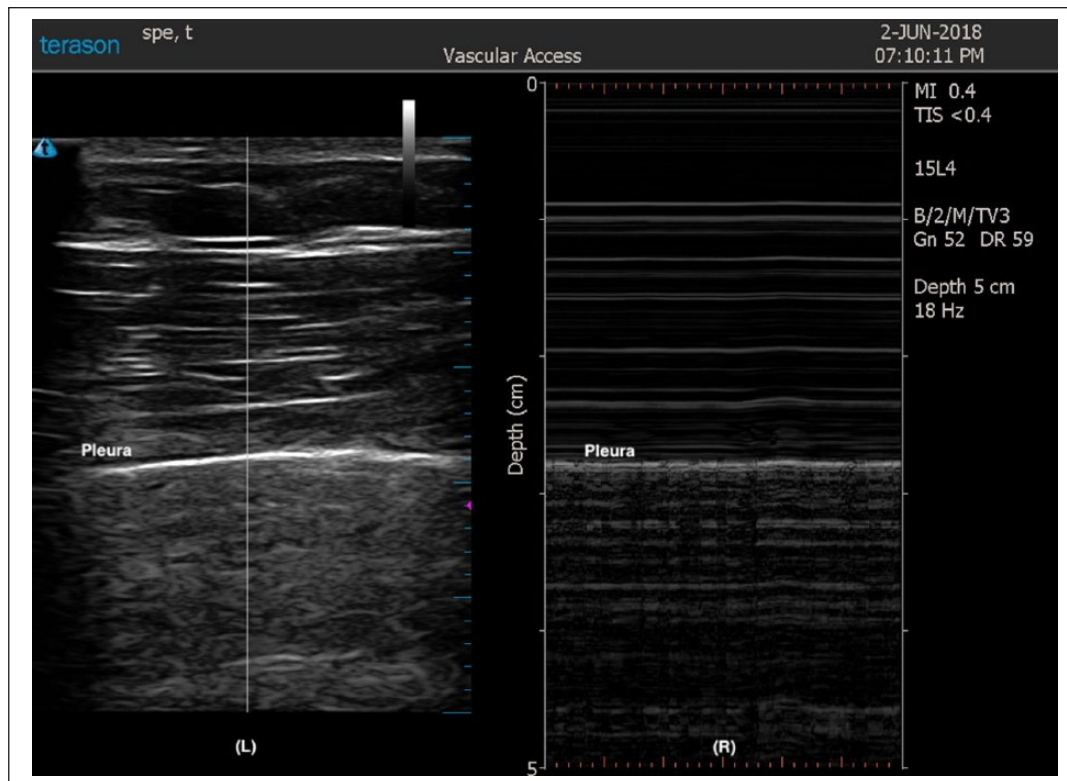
Step 7—sliding lung assessment—this is performed both in the assessment phase and in the post-insertion phase for exclusion of pneumothorax. Intercostal spaces on the anterior chest (1 through 3) at the midclavicular line are assessed. The visceral–parietal pleural interface is evaluated in both B-mode and M-mode to demonstrate lung sliding and seashore sign, respectively. Lung ultrasound demonstrating lung sliding of the visceral–parietal pleural interface in B-mode (L) and seashore sign in M-mode (R): image courtesy of T.R.S.
